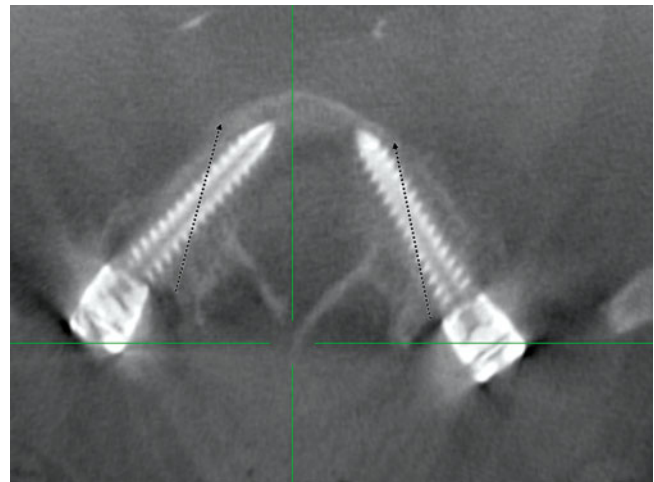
Axial intraoperative CT scanner scan image of an L5 vertebral body demonstrating the projected pedicle screw trajectory in open technique (*dotted lines*) and actual percutaneously inserted screw. Because of a more lateral entry point afforded by percutaneous pedicle screw placement, the supradjacent facet joint can be avoided
